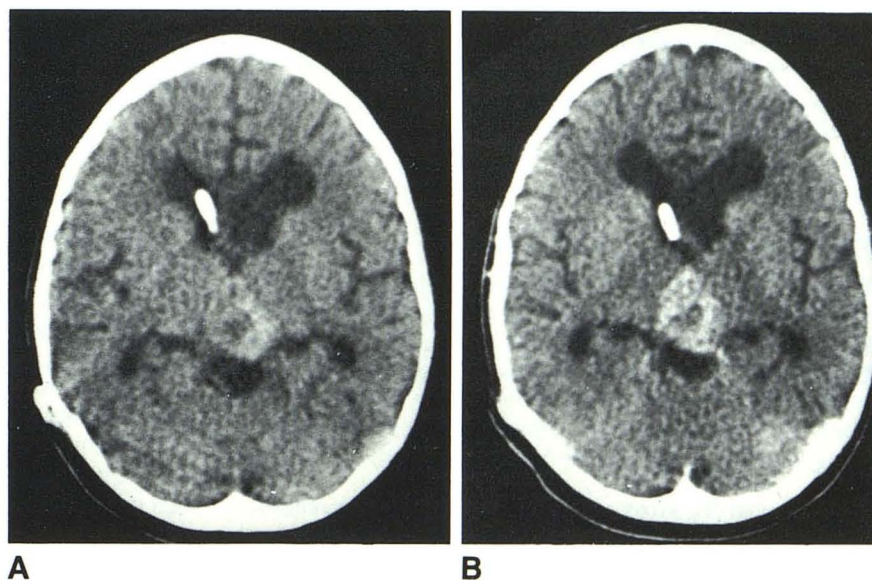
Pineoblastoma. A, Precontrast CT scan. Hyperdense mass with central lucency in pineal area, mild hydrocephalus, and shunt tip in right frontal horn. B, Postcontrast scan. Enhancement with central lucency probably representing necrotic area.
